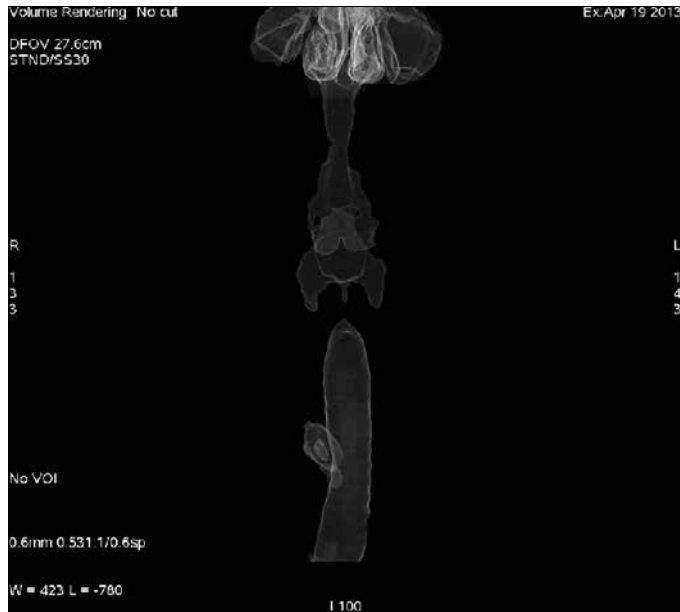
On 3D VR CT imaging, right paratracheal diverticulum from the antero-posterior aspect
